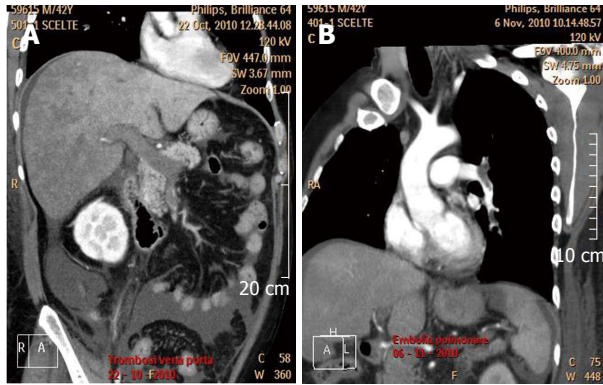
Computed tomography scan showing portal vein thrombosis (A) and a pulmonary embolism (B) in a patient with active ulcerative colitis.
